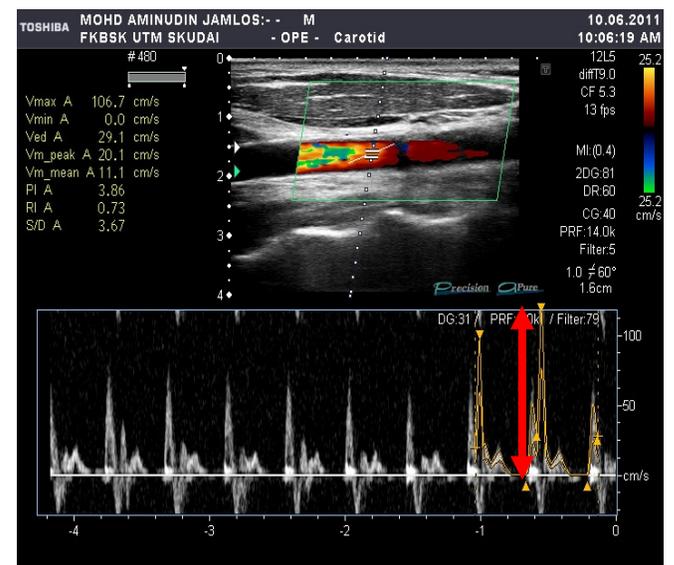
Stimulated (exercise) Doppler carotid artery image
